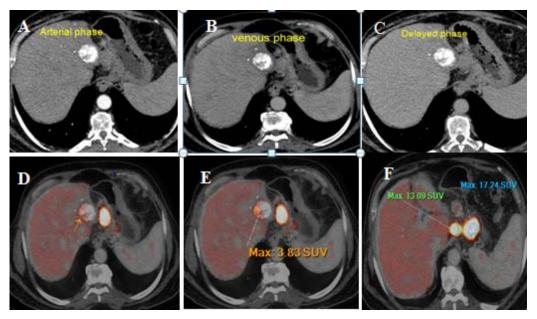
Sixty years old male patient, presented with history of liver cirrhosis and hepatic focal lesion for which TACE was done and serial AFP level was raising. A, B, C CECT phases show no abnormality with good lipiodol concentration however at D and E fused PET/CT image, hyper metabolic focal uptake at lateral aspect of the chemo-emoblized lesion. F Axial fused PET CTT images showhypermetabolic metastatic upper abdominal L.Ns.
